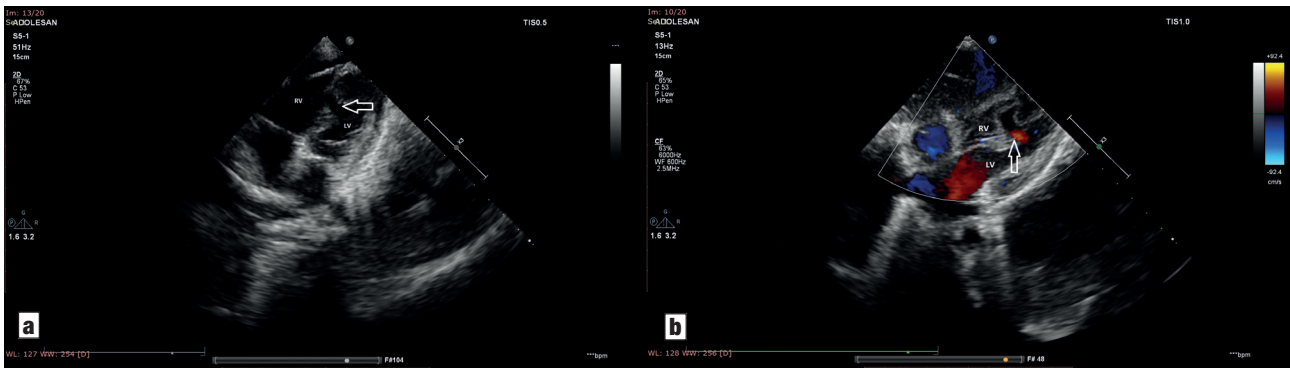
a. An aneurysm is observed between the two ventricles on subcostal four-chamber echocardiographic imaging and (b) colour flow mapping showed the flow jet bowing into the right ventricle during systole and the left ventricle during diastole without crossing the ventricular septum (arrows). LV = left ventricle, RV = right ventricle.
